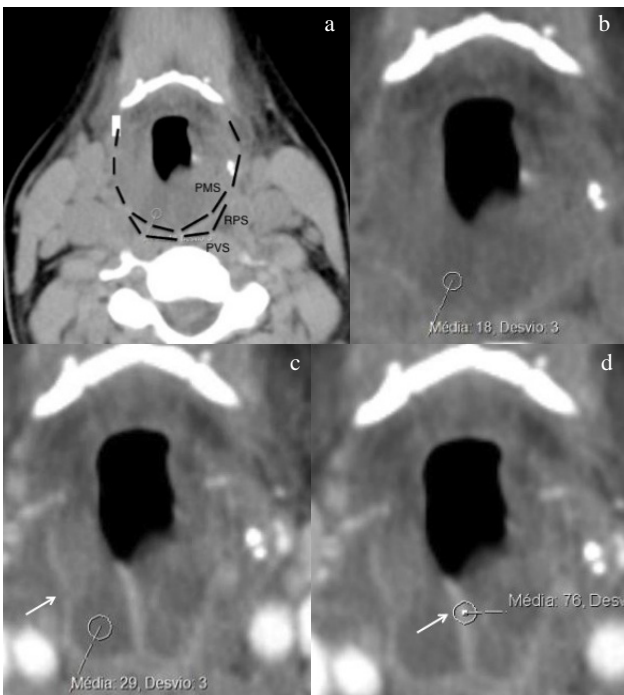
Pharyngeal mucosal space phlegmon/abscess. Axial pre (a, b) and post contrast (c, d) enhanced CT at the level of the hyoid bone, depicts marked thickening and hypodensity of the pharyngeal mucosal space, extending laterally, beyond the retropharyngeal limits. There is peripheral rim-like enhancement (arrow) although without a clearly fluid collection (clinic evolution confirmed this was an abscess (apagar)). PMS – parapharyngeal space; RPS – retropharyngeal space; PVS – prevertebral space.
